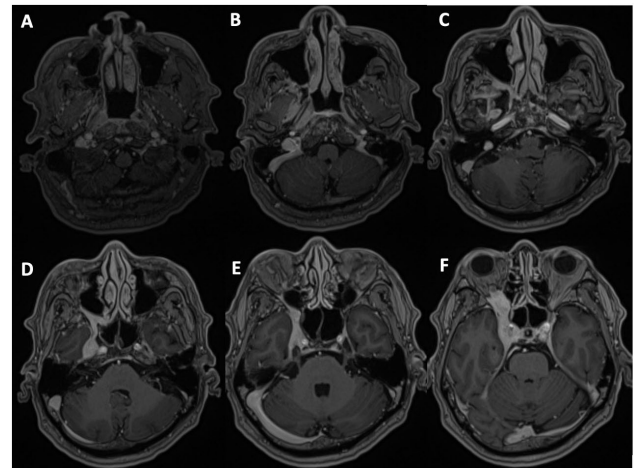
Axial MRI Brain in T1W fat-saturated post-Gadolinium sequence caudal cranially (A to F) showing an enhancing lesion in the right Fossa of Rosenmuller (A) with parapharyngeal and skull base involvement (B) and extensive perineural spread along foramen of ovale and vidian canal (C), foramen rotundum and pterygopalatine fossa (D), superior orbital fissure (F) and optic canal (E) causing orbital apex syndrome.
